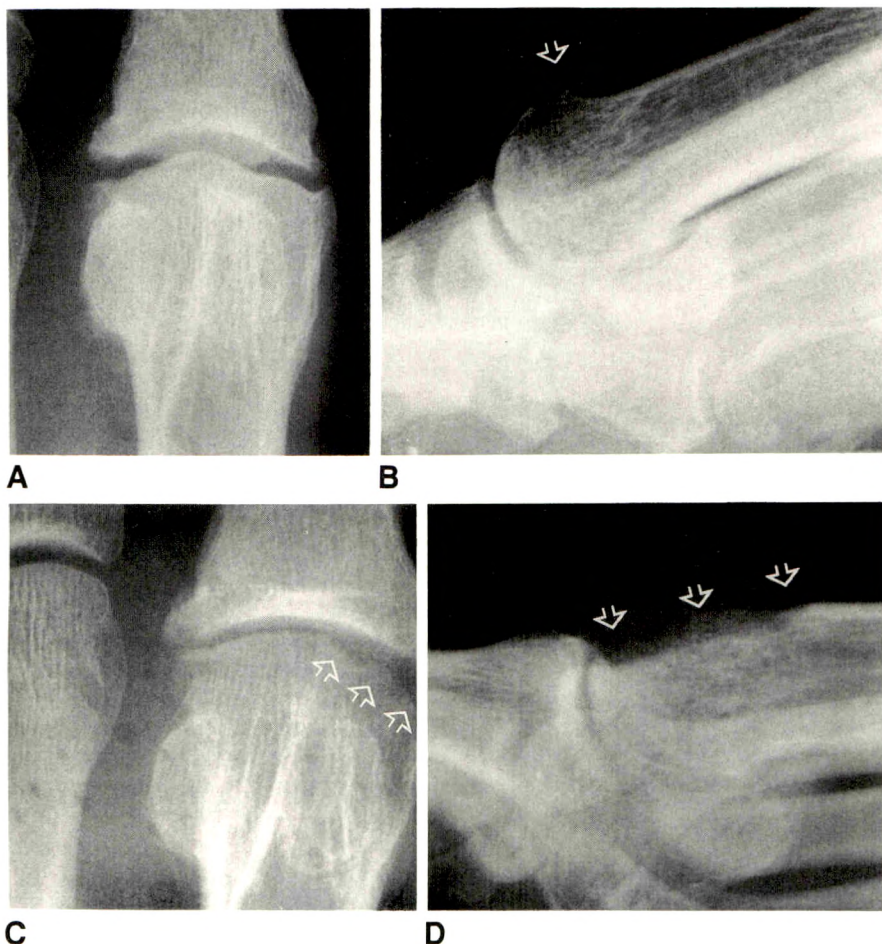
Radiographic findings after cheilectomy.
